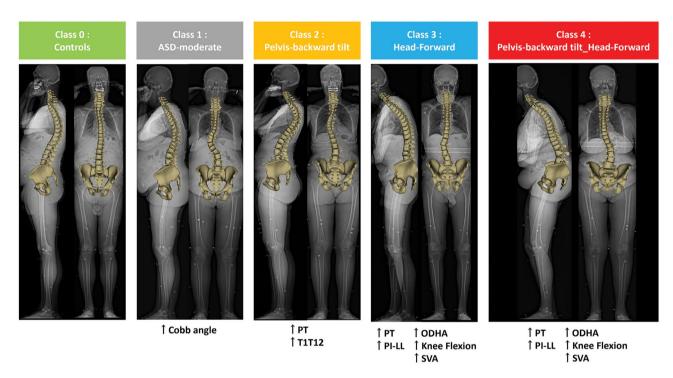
Examples of patients in each class with their most important radiographic features. (↑: increased, ↓: decreased).
